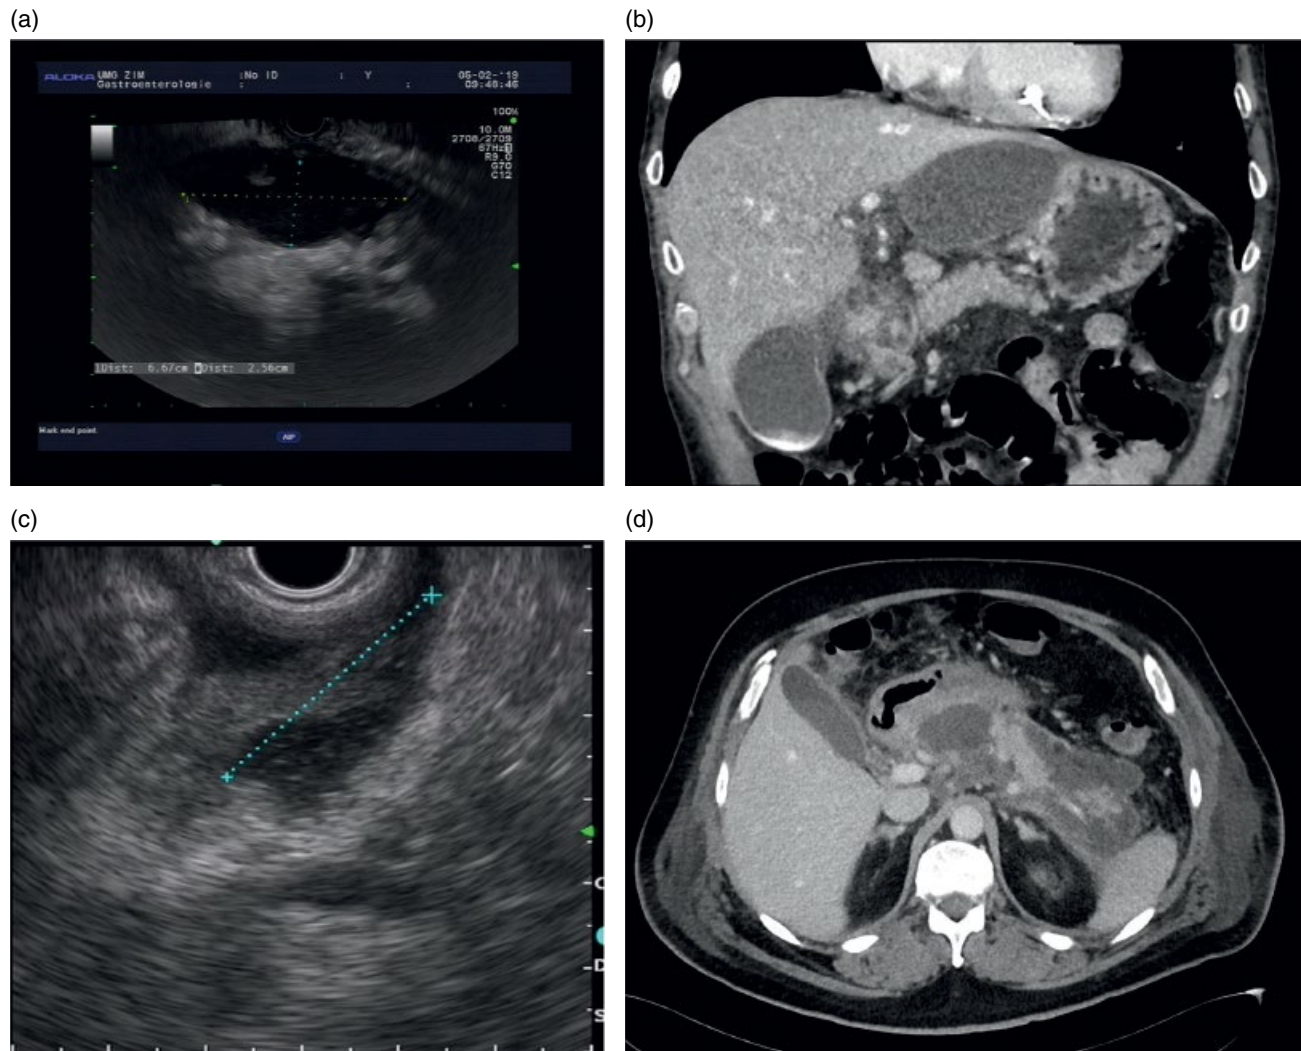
Examples for the occurrence of acute pancreatic fluid collections (APFC), post-acute pancreatic pseudocysts (PP), acute necrotic collection (ANC), and walled-off pancreatic necrosis (WOPN) on imaging. The upper panels depict an APFC on EUS (a), which later developed into a large, but oligo-symptomatic pseudocyst (b), demonstrated on a CT scan. The reader will appreciate the absence of solid debris within the collection. In contrast, the lower panel shows an ANC on EUS (c), which matured to a WOPN. On both images, the solid content is clearly visible. The CT scan (d) was obtained prior to percutaneous drainage of the collection, which was necessary due to infection.
